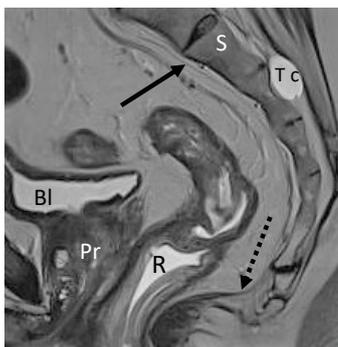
Midsagittal T2-w MR image of the posterior compartment for evidence of the presacral space: note the presacral fascia (black arrow) and the Waldeyer fascia (dotted arrow). Bl = bladder; Pr = prostate; R = rectal ampulla after evacuation of contrast (acoustic gel); S = sacrum; Tc = Tarlov cyst.
